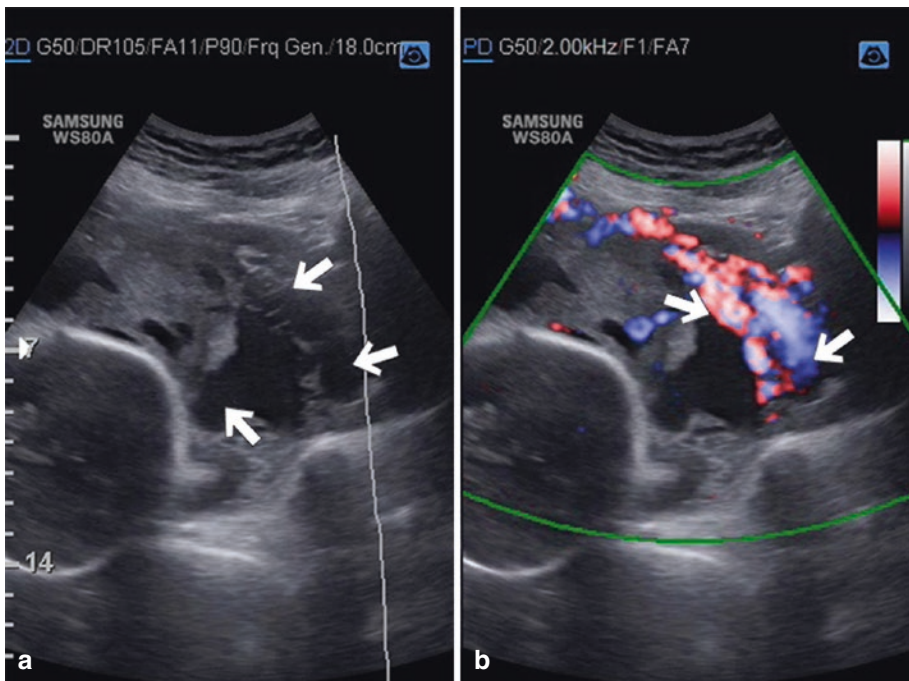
(a) Large and irregular Abnormal placental lacunae (arrow) in Transabdominal 2D ultrasound with (b) Placental lacunae feeder vessels (arrow) in 2D Doppler ultrasound (arrow) in 33 weeks of gestational age
